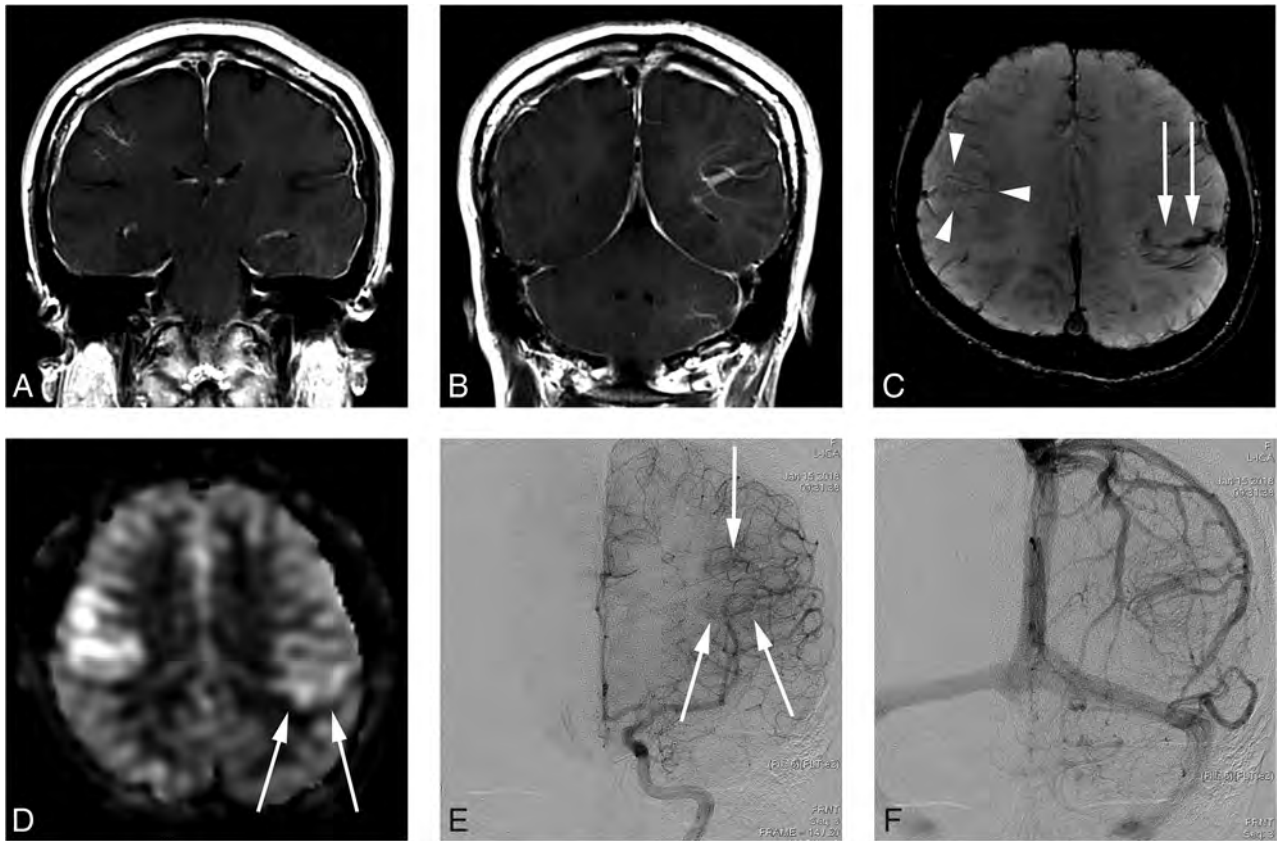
A 34-year-old woman presenting with a headache (case 6). *A* and *B*, Contrast-enhanced T1-weighted coronal MR imaging shows a DVA-like lesion in the bilateral parietal lobes. *C*, SWI demonstrates only hypointense signal in both the right (*arrowheads*) and left (*arrow*) lesions. *D*, The ASL quantitative CBF image demonstrates mildly hyperintense signal intensity in the parenchyma, corresponding to the location of the lesion. The left-sided lesion exhibits particularly subtle signal (*arrows*). *E*, In the late arterial phase of DSA, dilated medullary veins are gradually and subtly visualized (*arrows*). *F*, In the venous phase, dilated medullary veins draining to a collecting vein typical of a DVA are seen.
